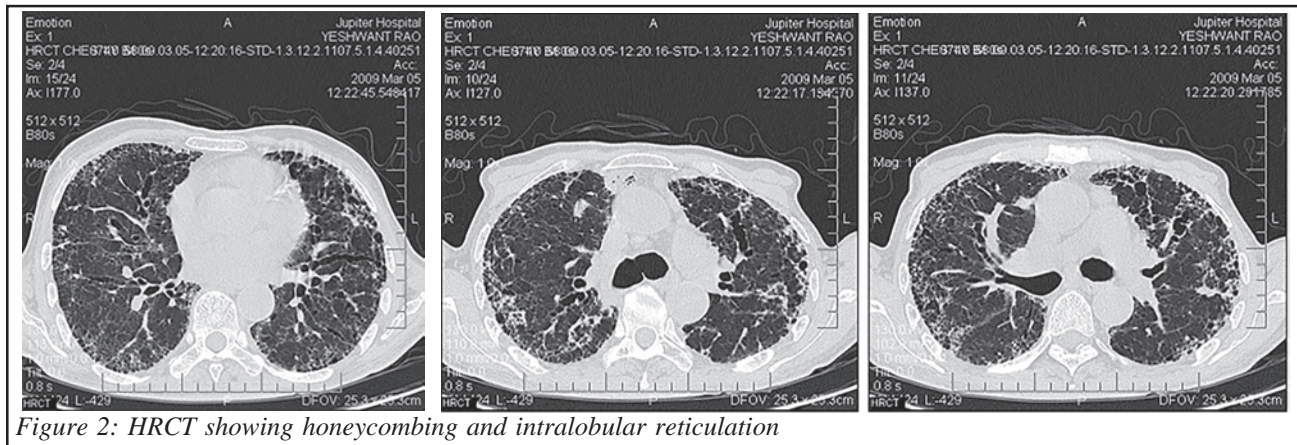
HRCT showing honeycombing and intralobular reticulation
